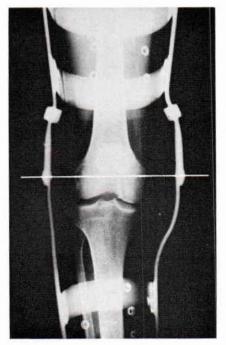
X-ray of knee showing alignment of the hinges. (From von Wersswetz (9), courtesy of Archives of Physical Medicine)
